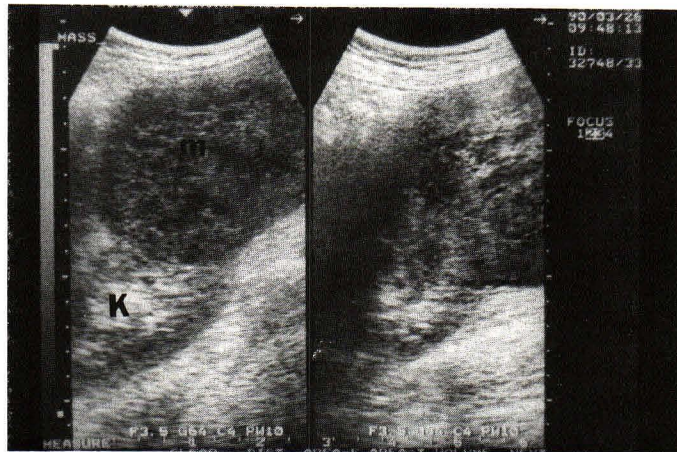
A longitudinal sonogram shows a complex mass (m) at the lower pole of the kidney
